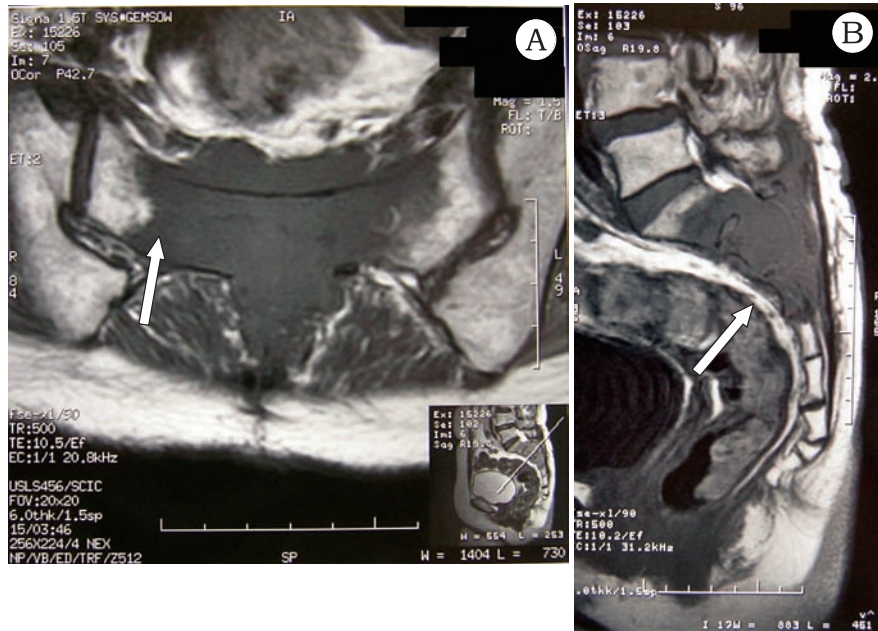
Magnetic resonance imaging (MRI) on admission demonstrates a huge isointense sacral mass (arrows) compared with the surrounding muscle which replaces a greater part of the sacrum. Axial (2A) and sagittal (2B) views of T1-weighted images (WI) of the sacral mass. Invasion of the mass into spinal canal and compression of thecal sac are seen.
